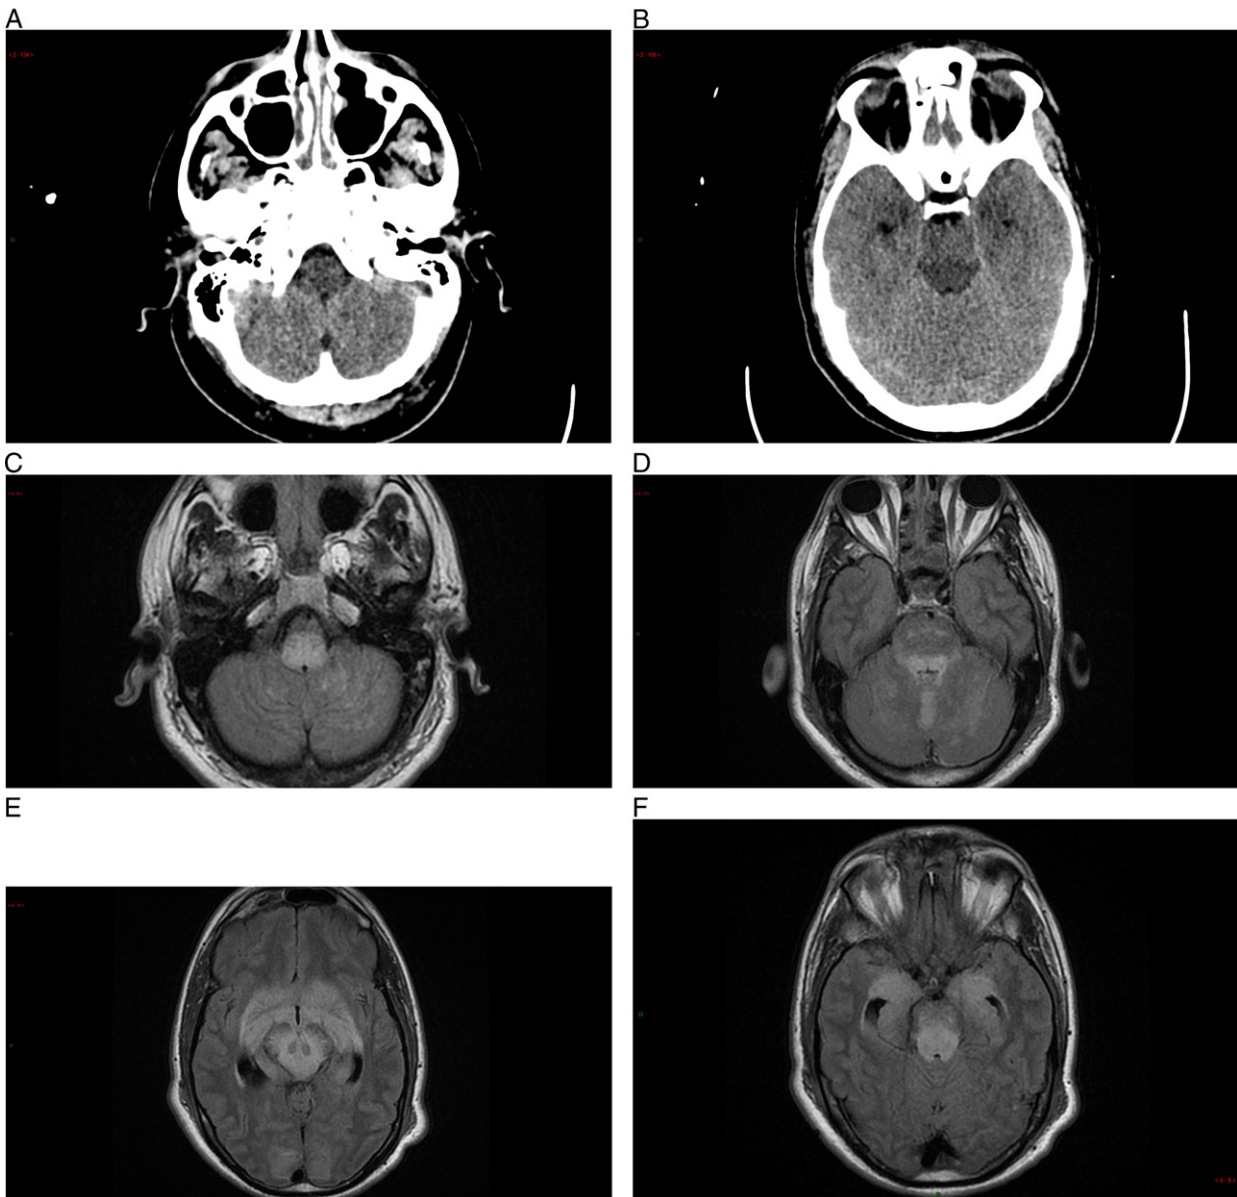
A–J — Brain imaging in Case 1. Non-enhanced CT-scan obtained 24 h after EG ingestion, shows hypodensity of the medulla (A) and the posterior pons (B). MRI at day 3: FLAIR shows hyperintensity of the medulla (C), the posterior pons and cerebellum (D), midbrain, sparing the red nuclei and the cortico-spinal tracts (E) medial temporal lobe (Amygdala, hippocampi, parahippocampi gyrus) (F), the thalami, the caudate and lenticular nuclei, the posterior limb of the internal capsule and the external capsule (G). Note the enlarged temporal and occipital horns of the lateral ventricles secondary to the third ventricle compression. Diffusion-weighted images show hyperintensity of the tectum of the medulla (H), pons and amygdala (I), thalami and lenticular nuclei (J). The apparent diffusion coefficient map shows high values at the same areas (K). L–M: MRI at 36 h in Case 2. FLAIR shows hyperintensity of the tectum of the pons (K) and the lenticular and caudate nuclei, thalami and hippocampi (L). Diffusion shows slight hyperintensity at the dorsal pons (M).
